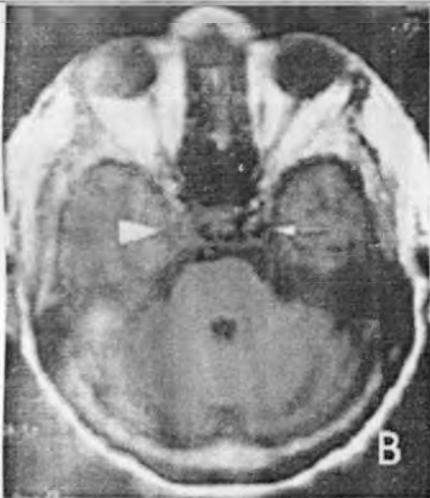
(B): Absent carotid artery flow on MRI in another patient. There is a black signal in the left internal carotid artery (small white arrow)
